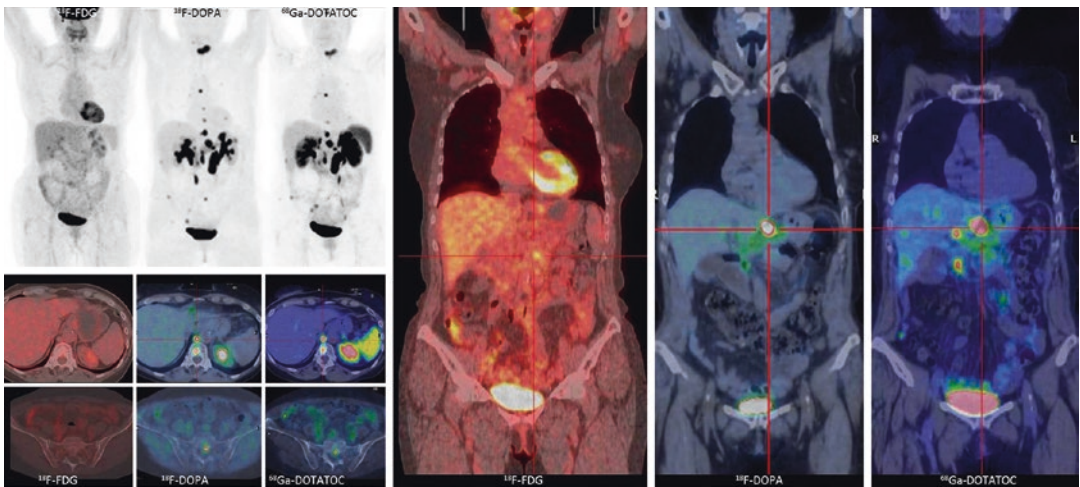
This picture summarizes ^{18}F -FDG, ^{18}F -DOPA, and ^{68}Ga -DOTATOC PET/CT findings in a patient with multiple secondary localizations and rise of *Chromogranin A* serum level, 2 years after surgical excision of a cecal carcinoid. The PET maximum intensity projections (MIP) (in gray scale) of the ^{18}F -FDG PET/CT is negative while the ^{18}F -DOPA and ^{68}Ga -DOTATOC MIP display numerous sites of pathologic tracer uptake in liver, bones, and multiple lymph nodes. On a per lesion analysis, a substantial
